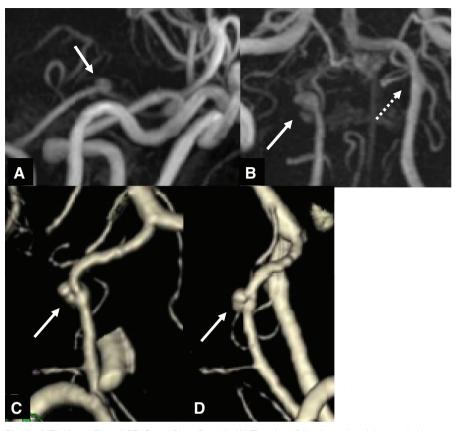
MRI (A and B) and CT (C and D) on Day 19. (A) The size of the dissecting right vertebral artery aneurysm had increased to 3.5 × 4.5 mm (solid arrow). (B) Enlargement of the dissecting right vertebral artery aneurysm (solid arrow) was noted, whereas there was no change in wall irregularity in the left vertebral artery (dotted arrow). (C and D) Bleb formation was observed in the dissecting right vertebral artery aneurysm site (solid arrow).
